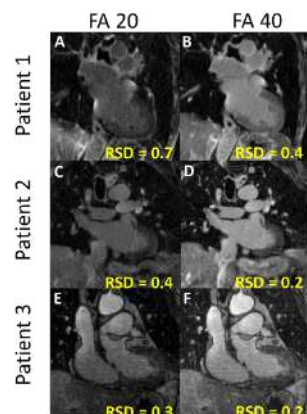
Representative LGE MRI examples and RSD calculations of three different patients with FA 20 imaging and FA 40.
